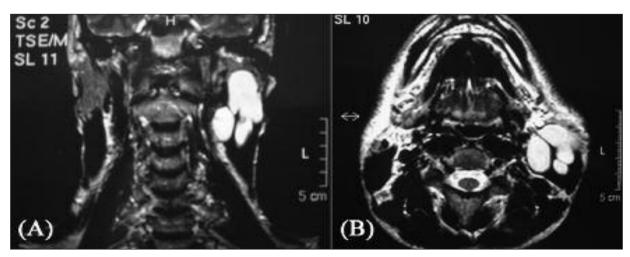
The neck MRI revealed a 5 x 3 cm in diameter septal cystic mass with indistinct walls; (A) coronal, (B) axial.
